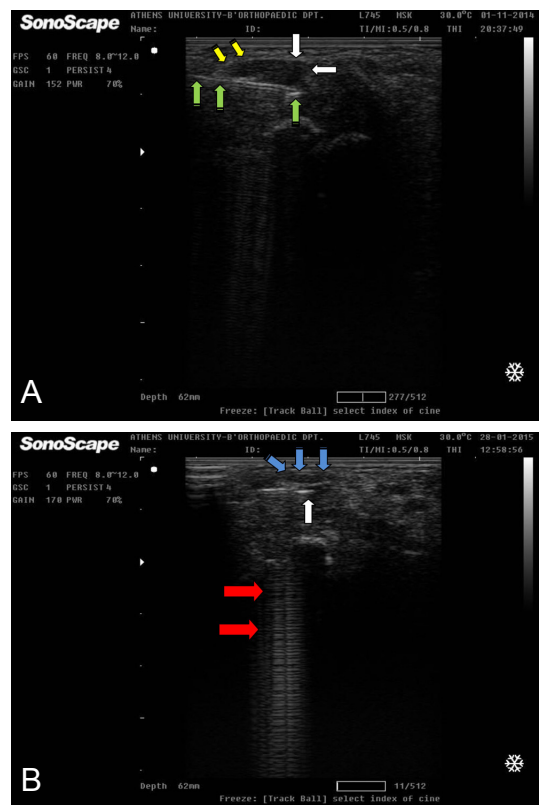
Ultrasound-guided injection of PRP.
